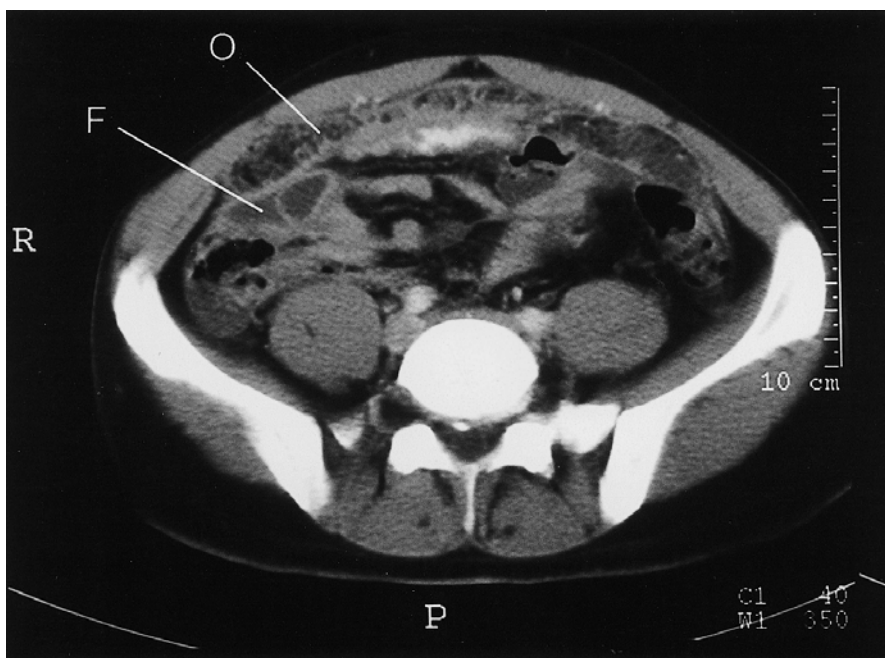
Abdominal computed tomography showing thickened omentum (O) and fluid (F) adjacent to the terminal ileum in abdominal tuberculosis.
